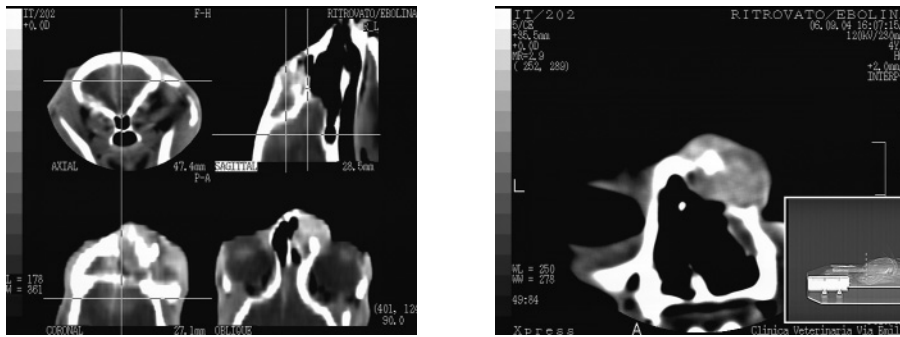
axial, sagittal and coronal CT sections of the frontal and orbital region with contrast enhancement showing the tumour.
